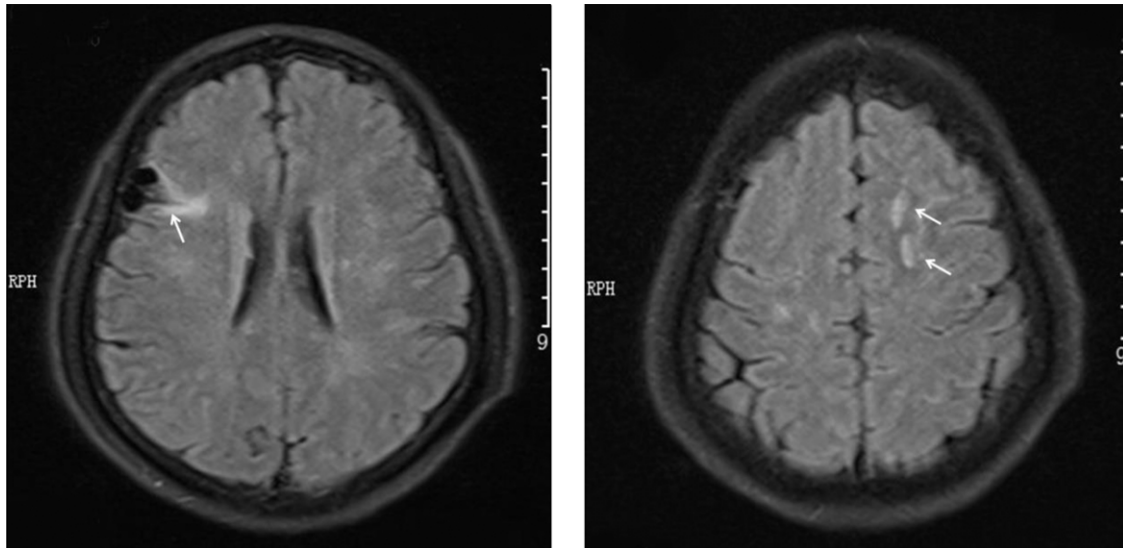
T2-FLAIR magnetic resonance imaging showed abnormal signal in the right frontotemporal cortex-like track sign and in the left centrum semiovale as oval shape sign (white arrow).
